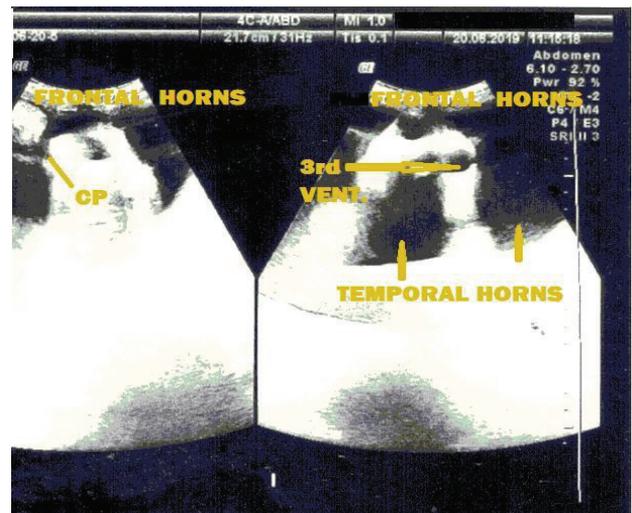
Ventricular Dilation: Coronal view ventricular system angled at 20° anteriorly; showing the neonatal brain and fluid, coronary plane of central 3rd ventricle was sonographically seen as a 32 mm anechoic margin. Observe the sonopenic/ echo-free superior frontal horns, inferior temporal horns and choroid plexus (CP) indentation on B-mode.
